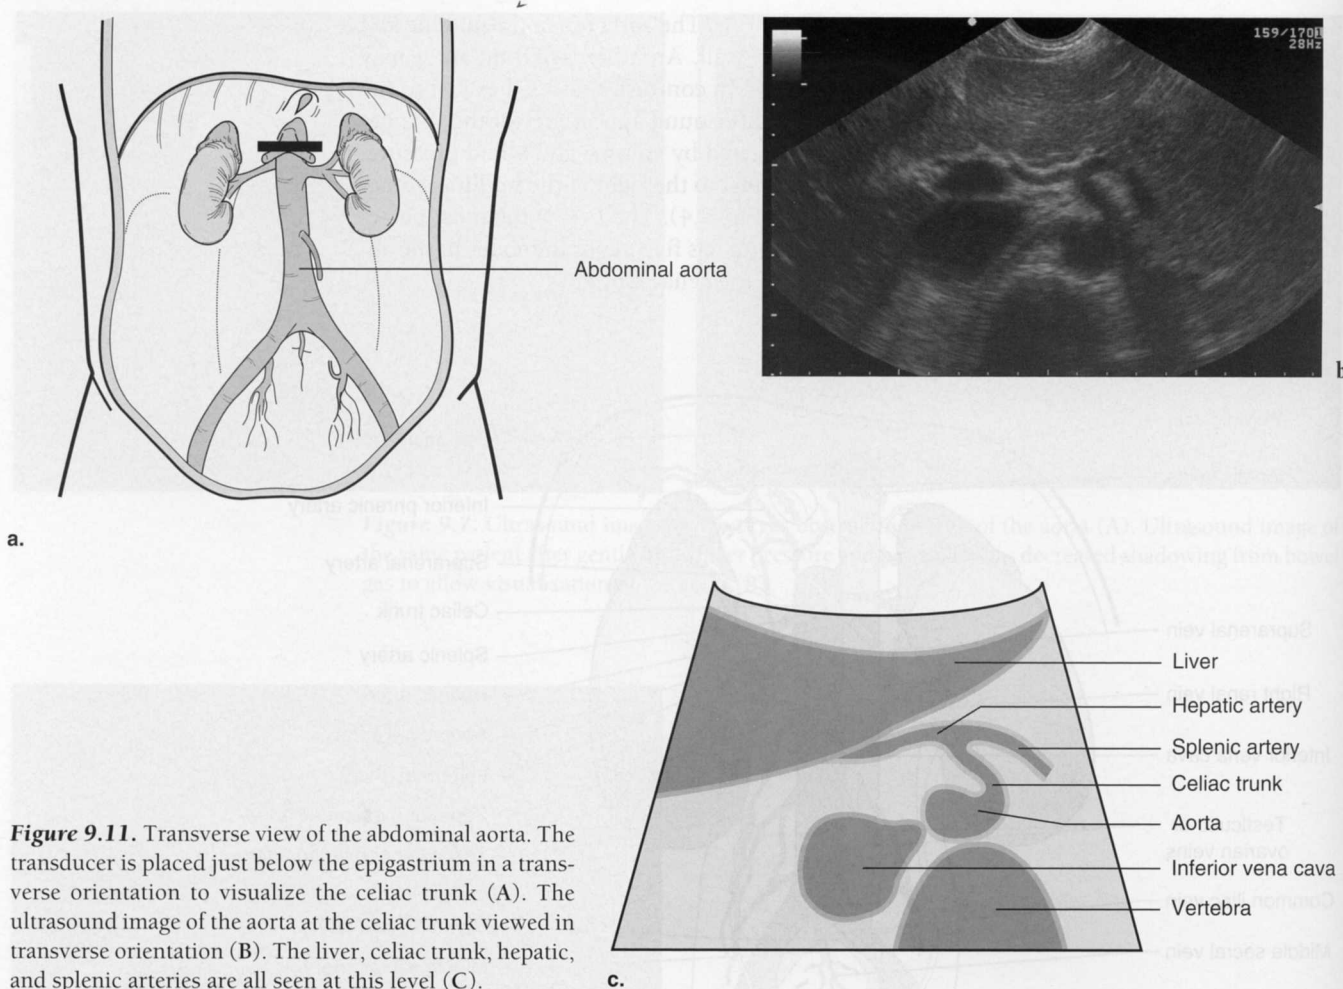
Transverse view of the abdominal aorta. The transducer is placed just below the epigastrium in a transverse orientation to visualize the celiac trunk (A). The ultrasound image of the aorta at the celiac trunk viewed in transverse orientation (B). The liver, celiac trunk, hepatic, and splenic arteries are all seen at this level (C).
